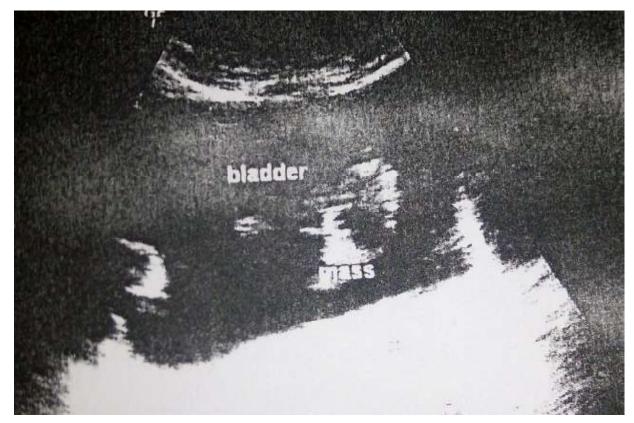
Showing abdomino-pelvic ultrasound scan of the bladder and intravesical mass
